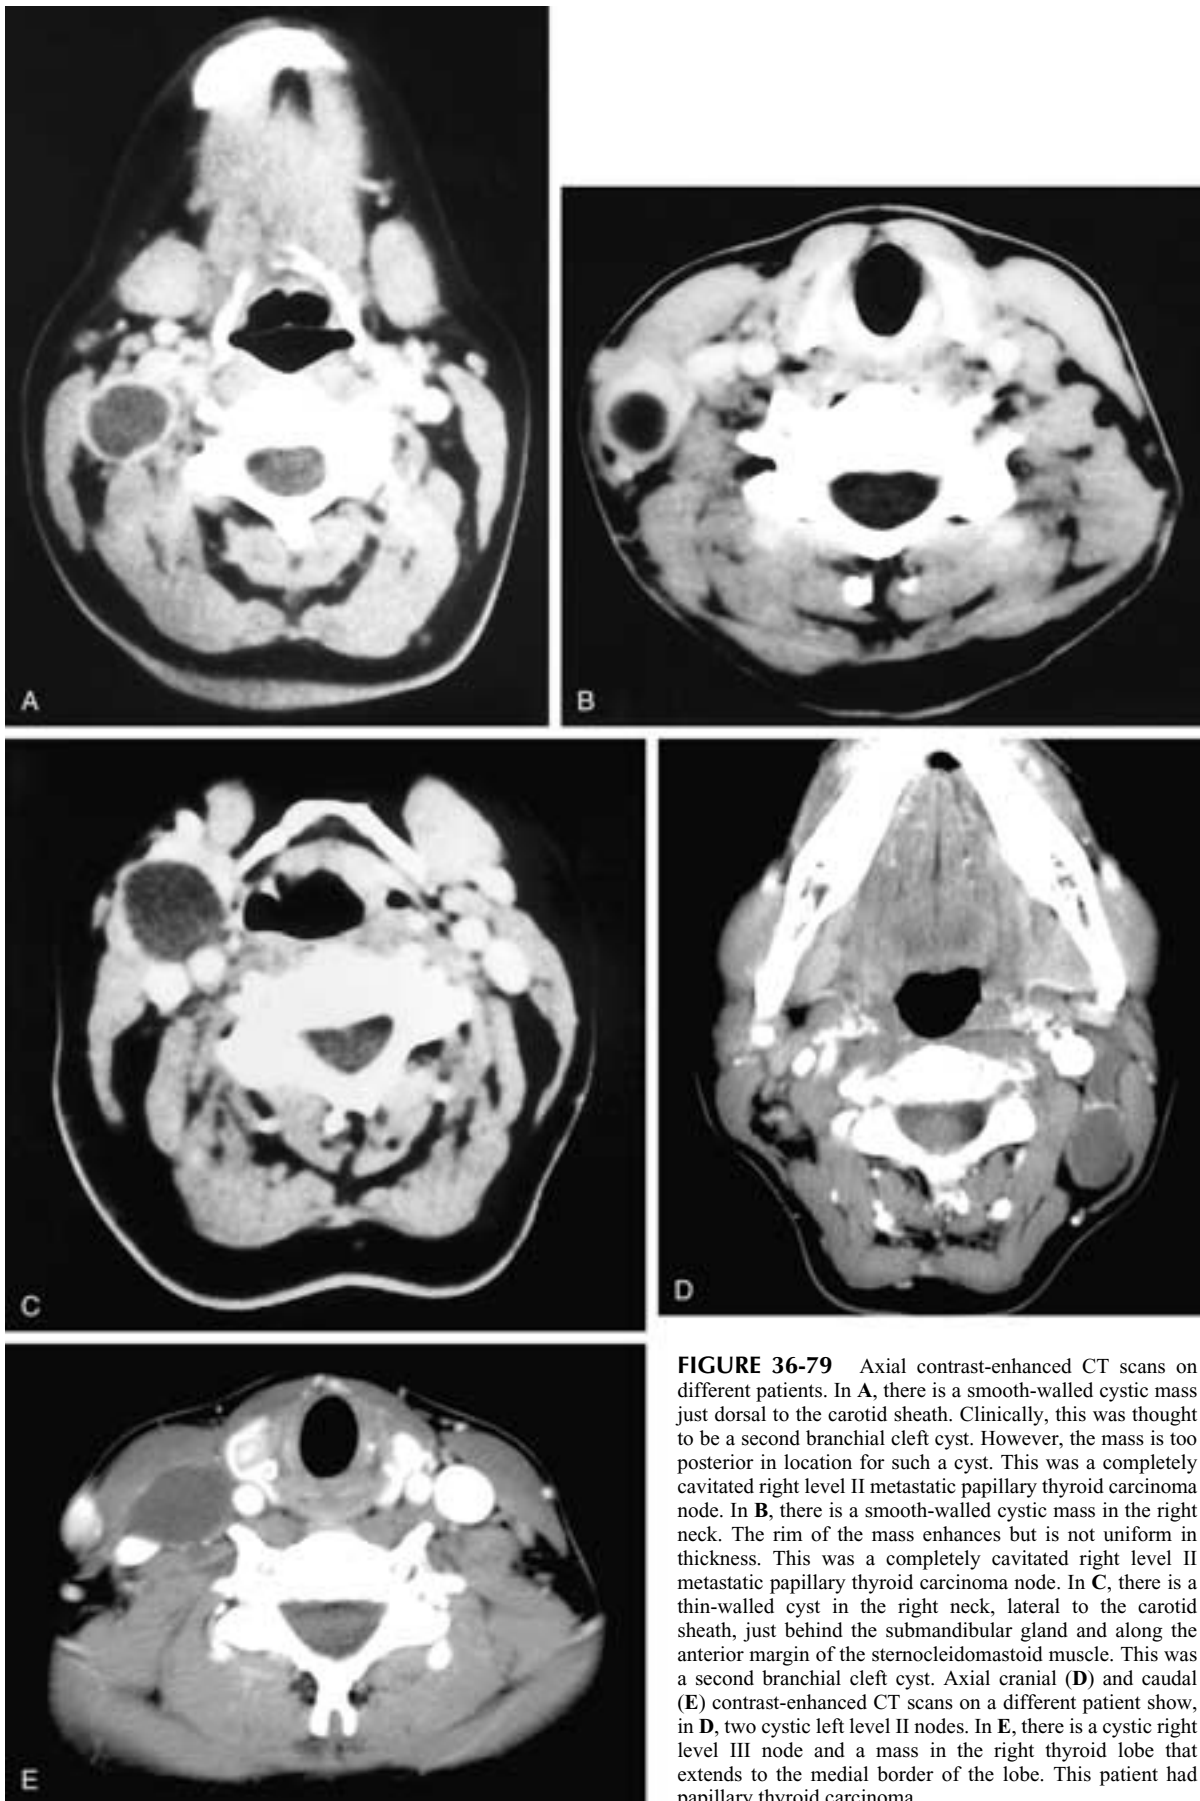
Axial contrast-enhanced CT scans on different patients. In A, there is a smooth-walled cystic mass just dorsal to the carotid sheath. Clinically, this was thought to be a second branchial cleft cyst. However, the mass is too posterior in location for such a cyst. This was a completely cavitated right level II metastatic papillary thyroid carcinoma node. In B, there is a smooth-walled cystic mass in the right neck. The rim of the mass enhances but is not uniform in thickness. This was a completely cavitated right level II metastatic papillary thyroid carcinoma node. In C, there is a thin-walled cyst in the right neck, lateral to the carotid sheath, just behind the submandibular gland and along the anterior margin of the sternocleidomastoid muscle. This was a second branchial cleft cyst. Axial cranial (D) and caudal (E) contrast-enhanced CT scans on a different patient show, in D, two cystic left level II nodes. In E, there is a cystic right level III node and a mass in the right thyroid lobe that extends to the medial border of the lobe. This patient had papillary thyroid carcinoma.
